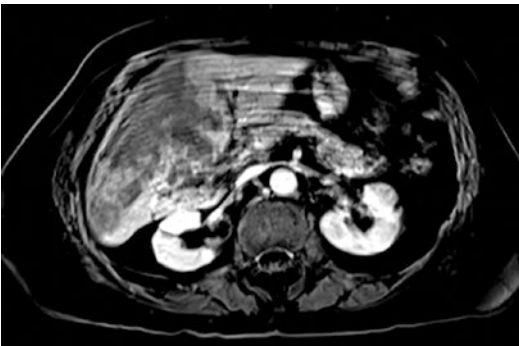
Gadolinium-enhanced, fat-suppressed T1-weighted image through the same liver is shown in Figs. 8.15/8.16. The large region of low (dark) signal within the liver corresponds with the region of restricted diffusion on prior images and is compatible with infarct. Note the diffusely low signal of fatty structures as a result of the fat-suppression technique
